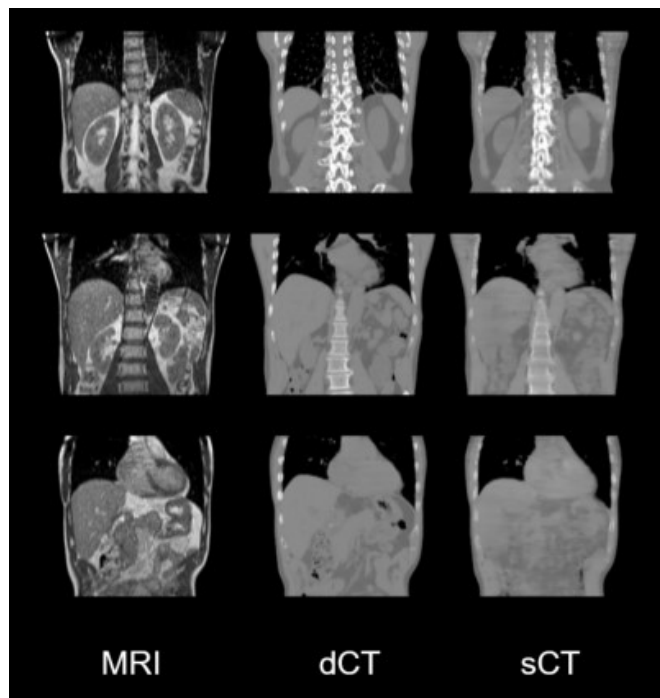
The representative coronal slice views of MRI, dCT and sCT for abdomen
